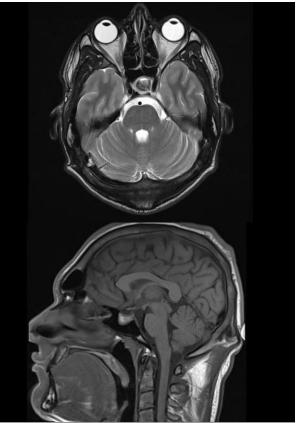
Preoperative MRI Transversal and sagital plane reaveal an inhomogenous pituitary tumor with hemorrhage and necrosis with maximum diameters of 15mm/12 mm/13 mm.
